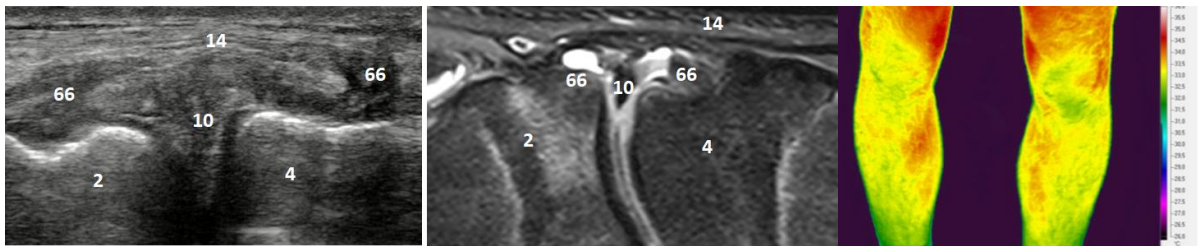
sono, Fig.7b.MRI, Fig.7c.TMV. Sono, MRI: extrusion of lateral meniscus with perimeniscal cysts on the left. TMV: a focus of increased thermal activity in the lateral part of the left knee. 2. condylus lateralis femoris, 4. condylus lateralis tibiae, 10. meniscus lateralis, 14. ligamentum collaterale laterale, 66. cyst.
